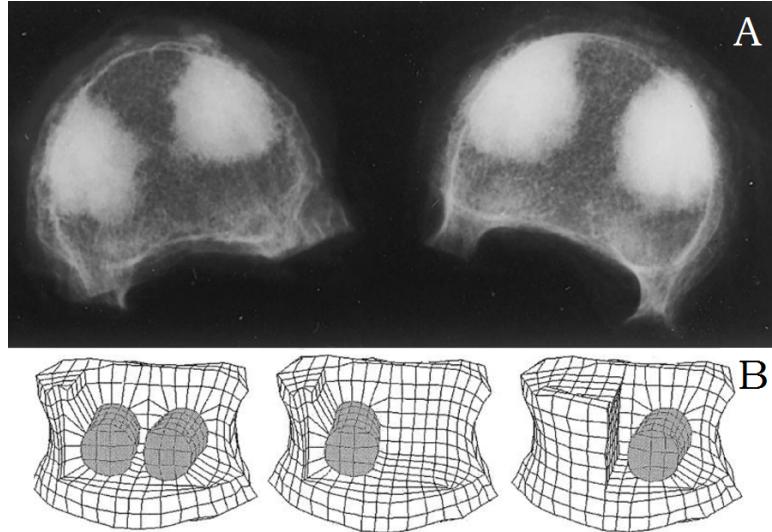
A: Top view μ CT scans of human vertebrae augmented *in vitro*, showing gradual reduction of cement opacity to the edges of the internal cement volume, adapted from Belkoff et al. [5]. B: The augmented model generation for the study carried out by Liebschner et al. [6].
